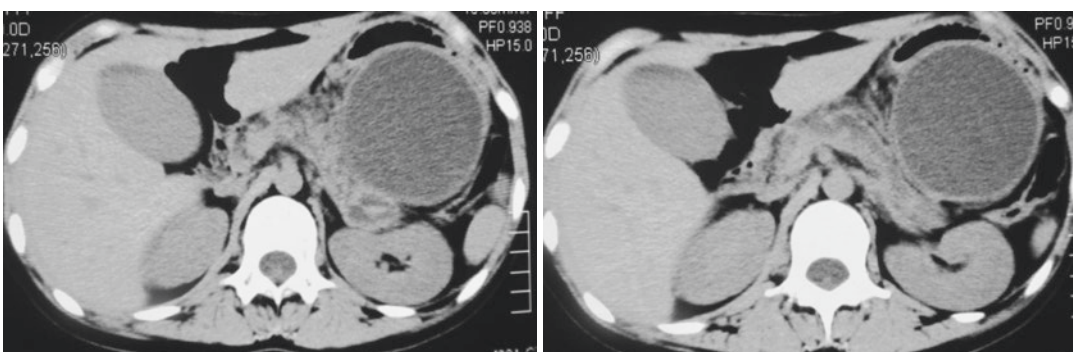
CT revealed pancreatic duct dilatation, multiple low-density shadows in the pancreatic head and tail suggestive of pancreatic pseudocysts up to 7 cm in diameter
